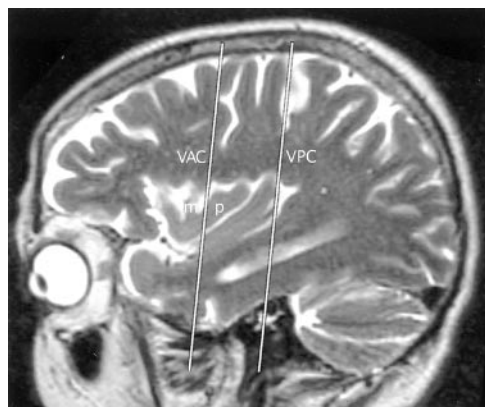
Talairach-Tournoux relationship of the insula. Sagittal T2-weighted MR image in a 26-year-old woman. The two vertical white lines indicate the insular intersections of the coronal planes erected perpendicular to the AC-PC baseline at AC (VAC) and at PC (VPC). VAC nearly always intersects the anterior lobule, most frequently in relation to the upper portion of the precentral sulcus between the MSG (m) and the PSG (p). VPC typically defines the posterior margin of the insula.
